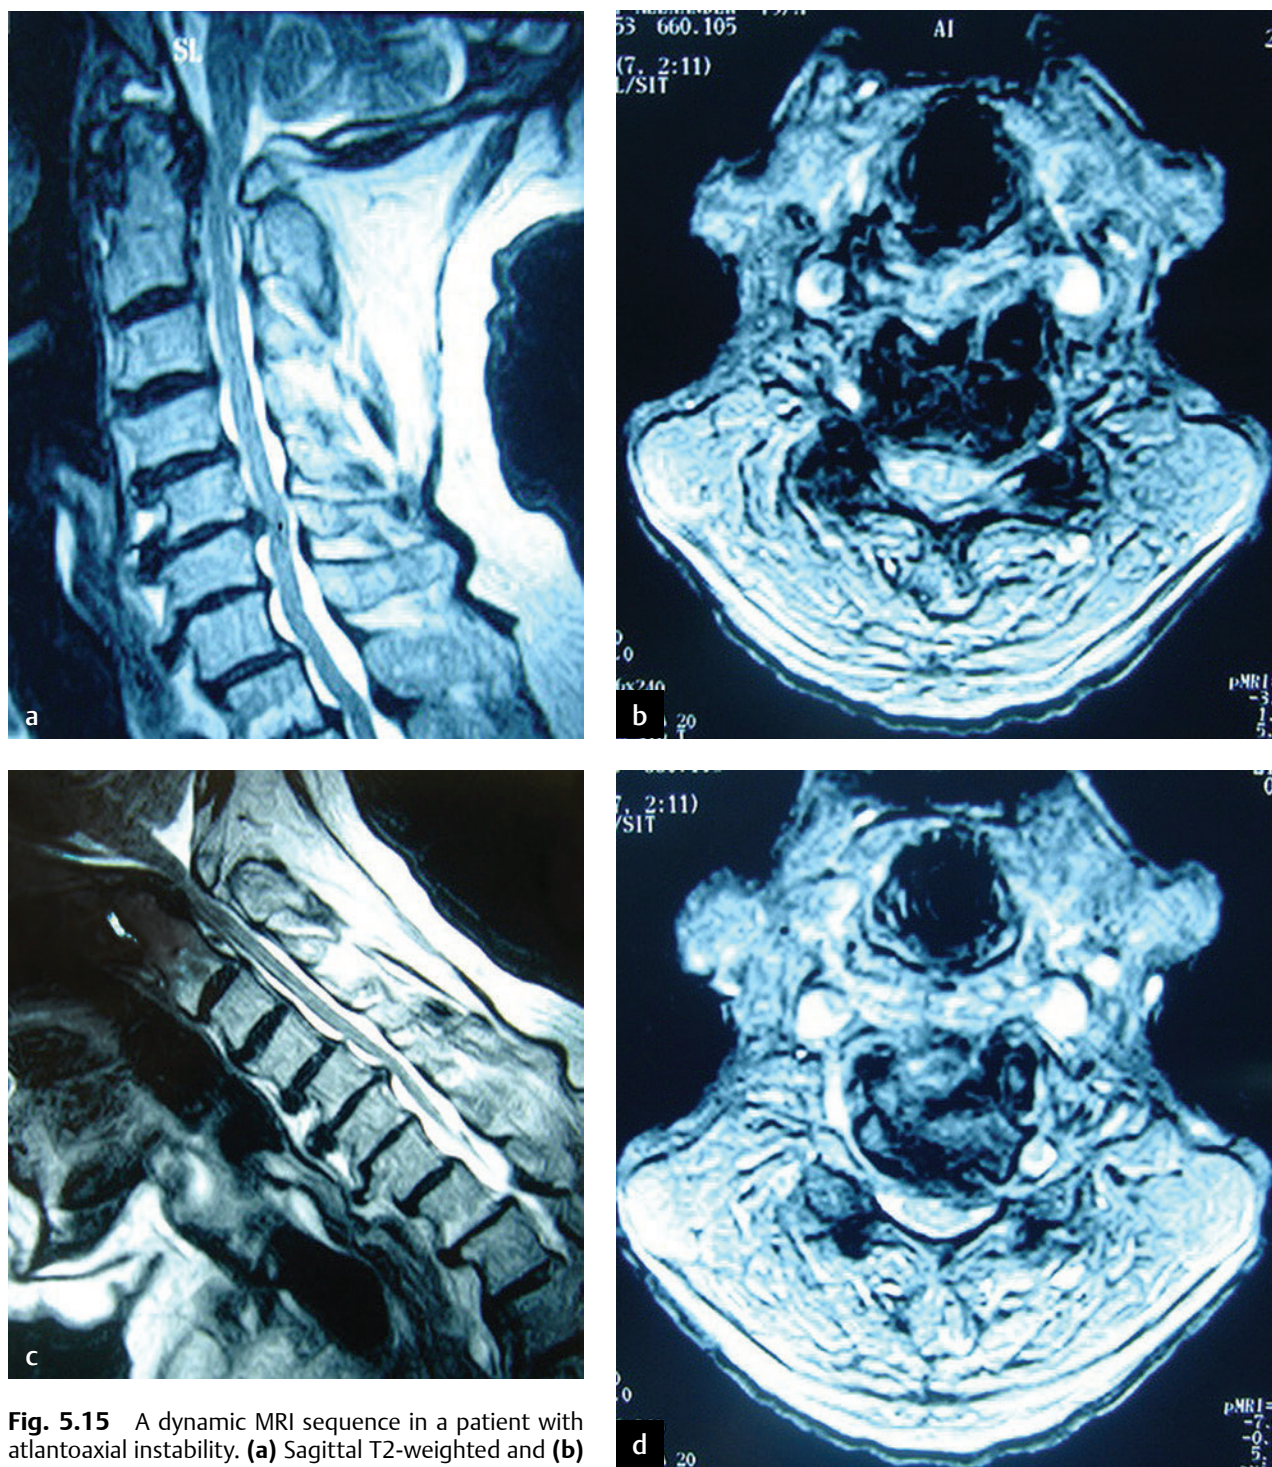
A dynamic MRI sequence in a patient with atlantoaxial instability. (a) Sagittal T2-weighted and (b) axial T2-weighted images in extension show only mild cord compression, whereas (c) sagittal T2-weighted and (d) axial T2-weighted images in flexion show severe cord compression and widening of the anterior atlanto-dens interval.
